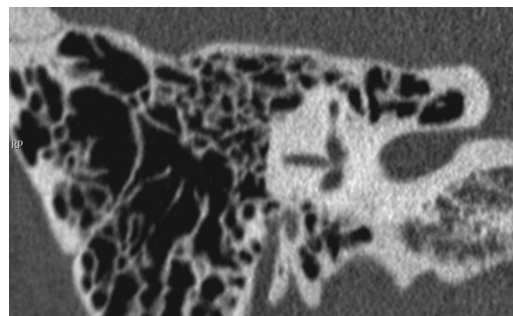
Coronal computed tomographic scan showing an example of a nondehiscent superior SCC, which is covered by supralabyrinthine air cells.
